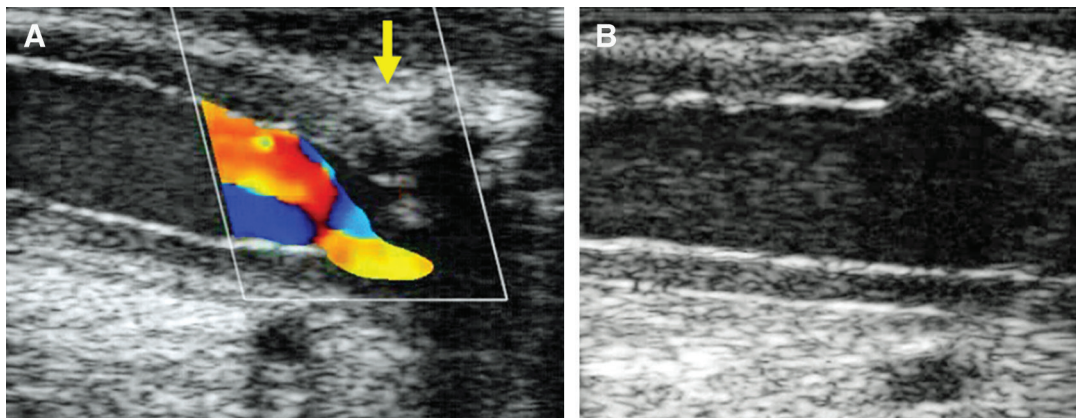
(A) Ultrasonography revealed stenosis at the cannulation site after decannulation. The arrow indicates the stenosis. (B) Stenosis was not observed after the femoral artery was repaired.
